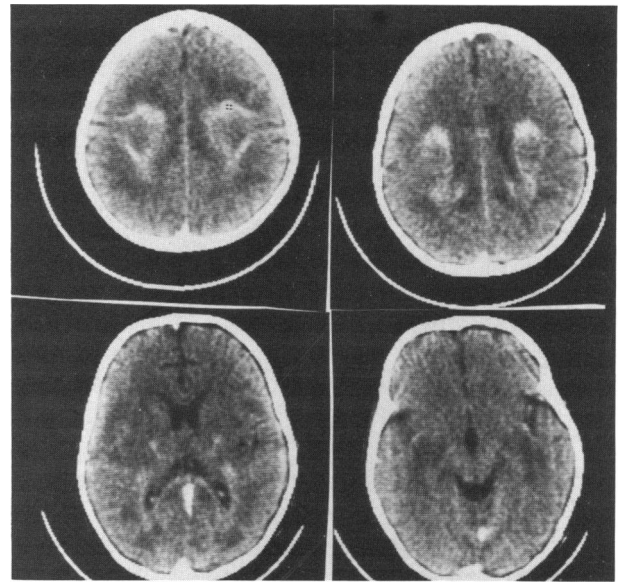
CT scan of patient 1 after contrast infusion at age 4 years. Note the abnormal contrast enhancement, especially bilaterally at the level of the centrum semiovale, and extensive white-matter hypodensities.
